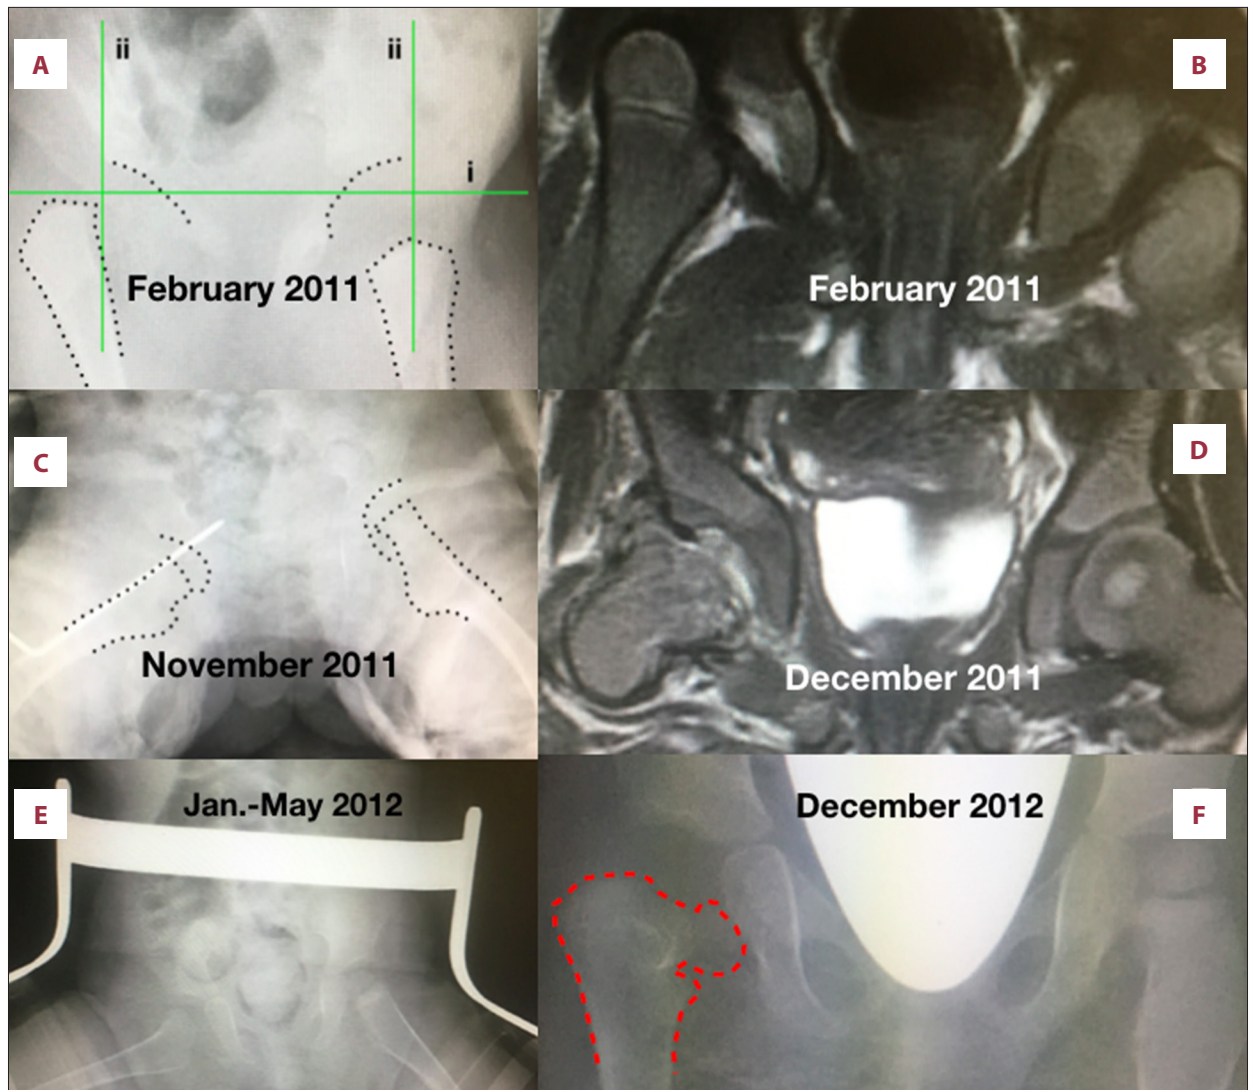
(A) The first X-ray of our patient, showing right hip dislocation. i=indicating Hilgenreiner line, ii=indicating Perkins line. (B) MRI showing the right hip dislocation. (C) X-ray of our patient after open reduction and use of hip-spica and K-wire for stabilization. (D) MRI of our patient showing collapse and fragmentation of the femoral head (AVN). (E) Abduction orthosis used 6 months after open reduction. (F) X-ray of our patient at 2 years of age. Femoral head necrosis is obvious.
